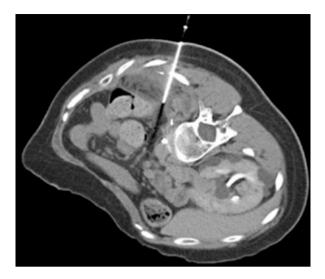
CT-guided cryoprobe for ablation
